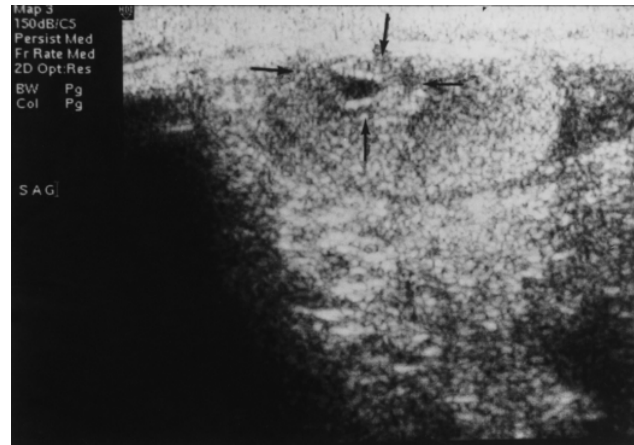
Ultrasonography of the right testis demonstrates an intratesticular mass (arrows indicate the mass).
